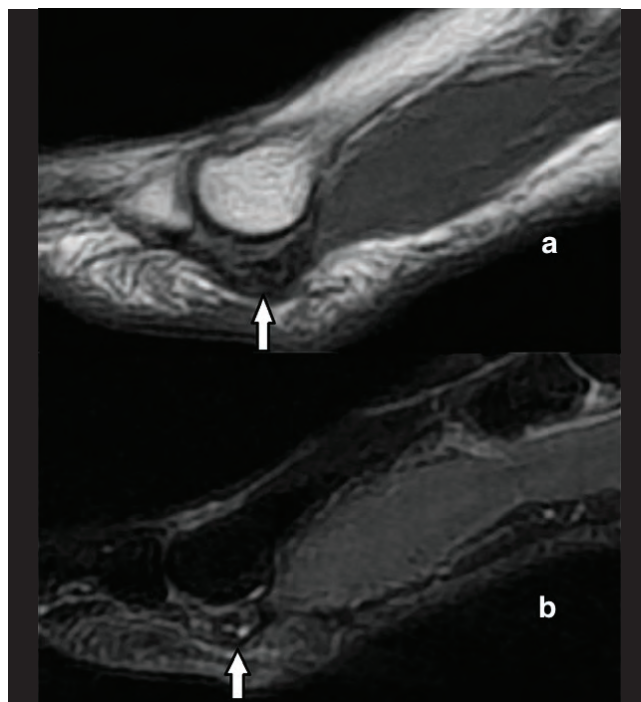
Decreased dimension and signal consistent are observed in the medial sesamoid bone in T1-weighted sequence (a) performed in the sagittal plane in magnetic resonance imaging (white arrow). Occasional hyperintense signals are observed in the osteonecrotic sesamoid bone in STIR sequence (b).
